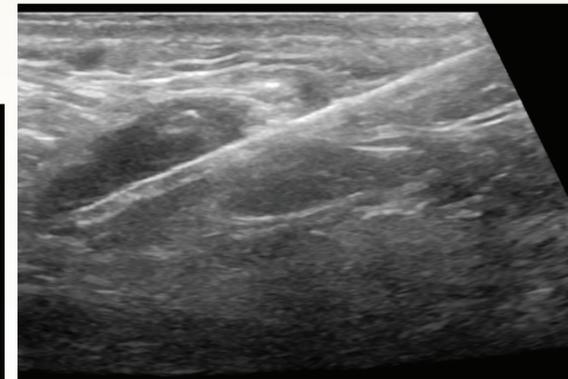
Ultrasound guided Biopsy of submandibular lymph node
